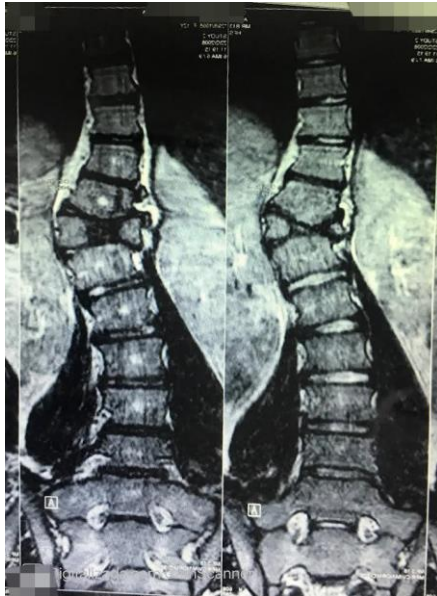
Nuclear magnetic resonance image evidencing the VH at T12 in the anterior position (b).
